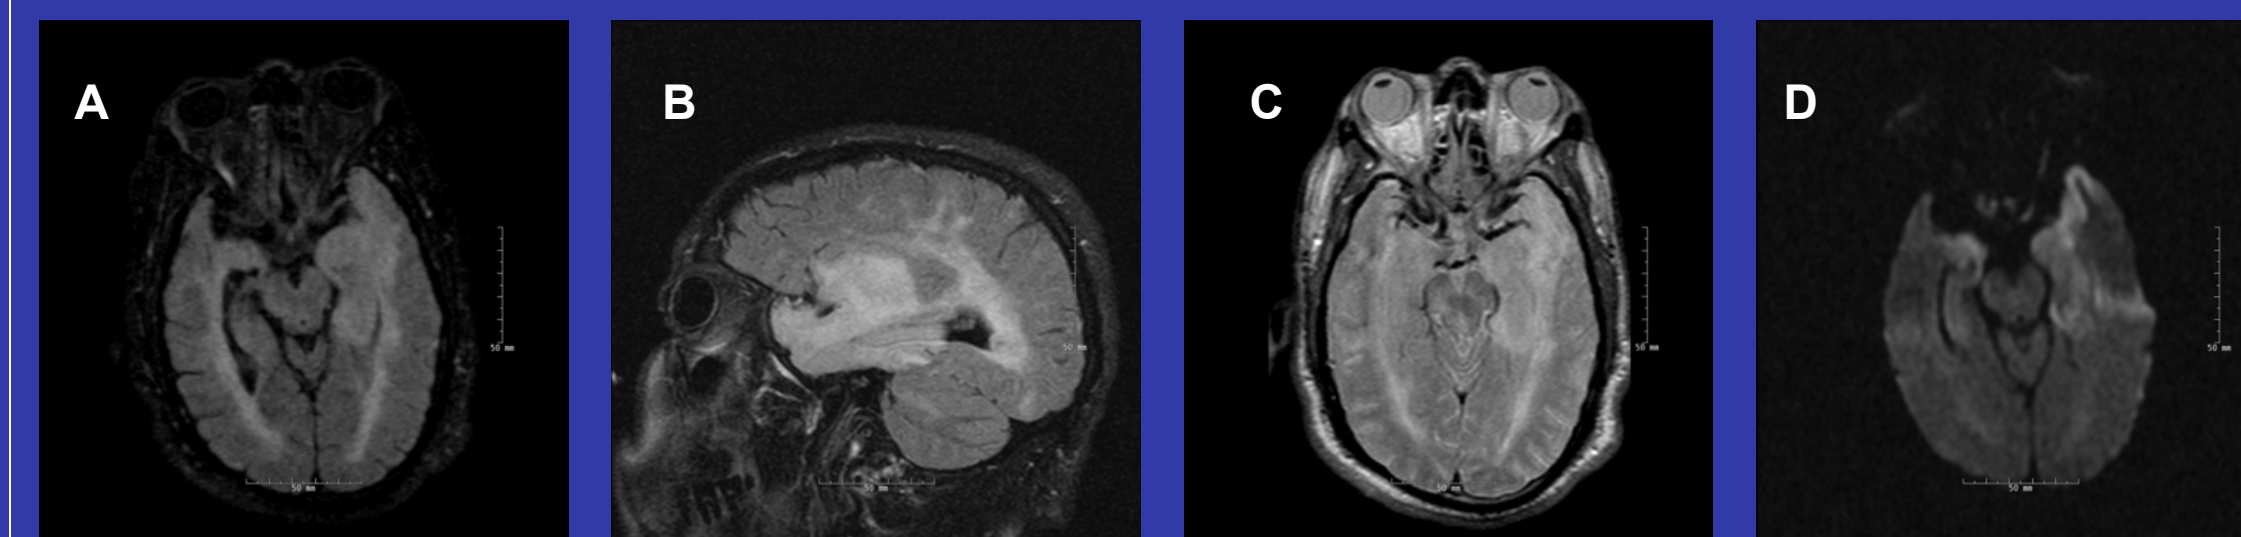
MRI Brain at the time of HSE onset. Confluent T2/FLAIR hyperintensity throughout the left temporal lobe with diffuse edema and enlargement of the left amygdala and hippocampal formation (A-C). New restricted diffusion on DWI in the left temporal lobe (D).
